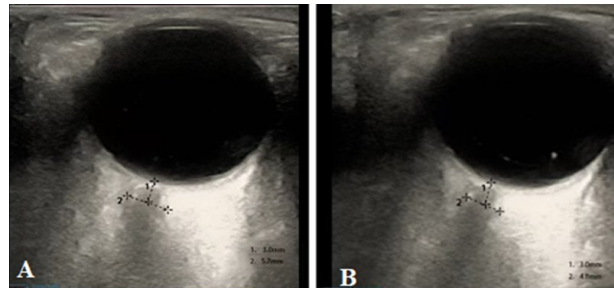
Ultrasonic (2D) Measurement of Neural Diameter in Patients with Severe Traumatic Brain Injury.
